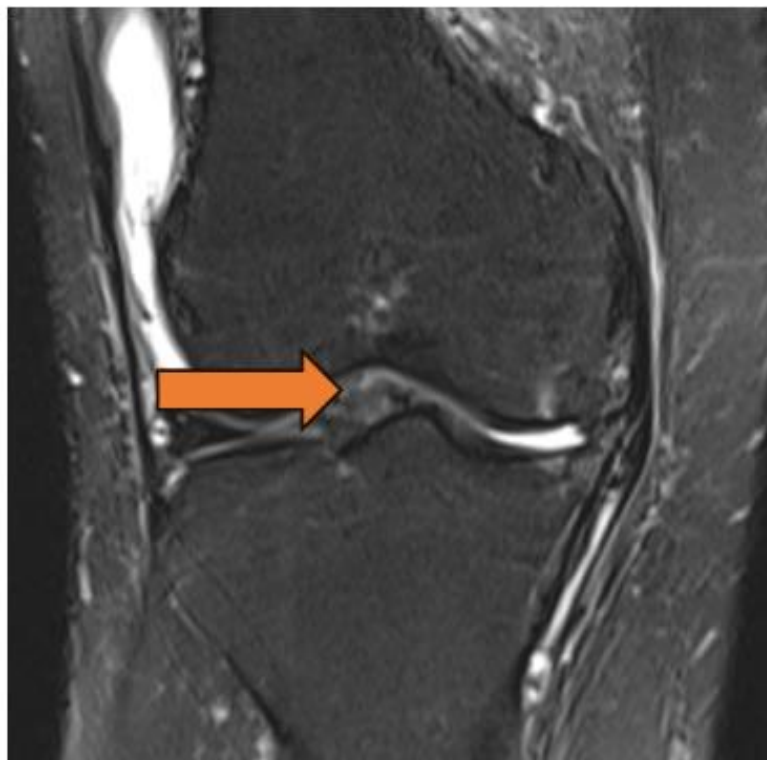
MRI Left knee joint PDFS sequence, coronal section shows Medial Collateral Ligament sprain
